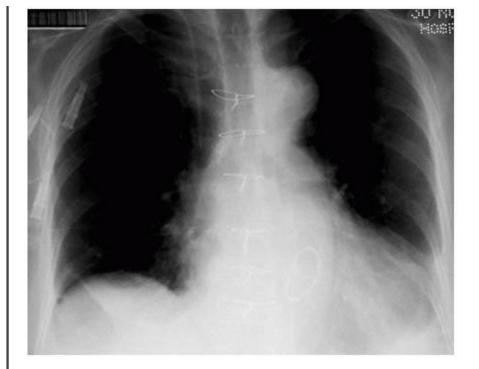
Radiograph showing an inadequate image quality. The lung fields appear too black and the apices of the lungs are not included in the image.
